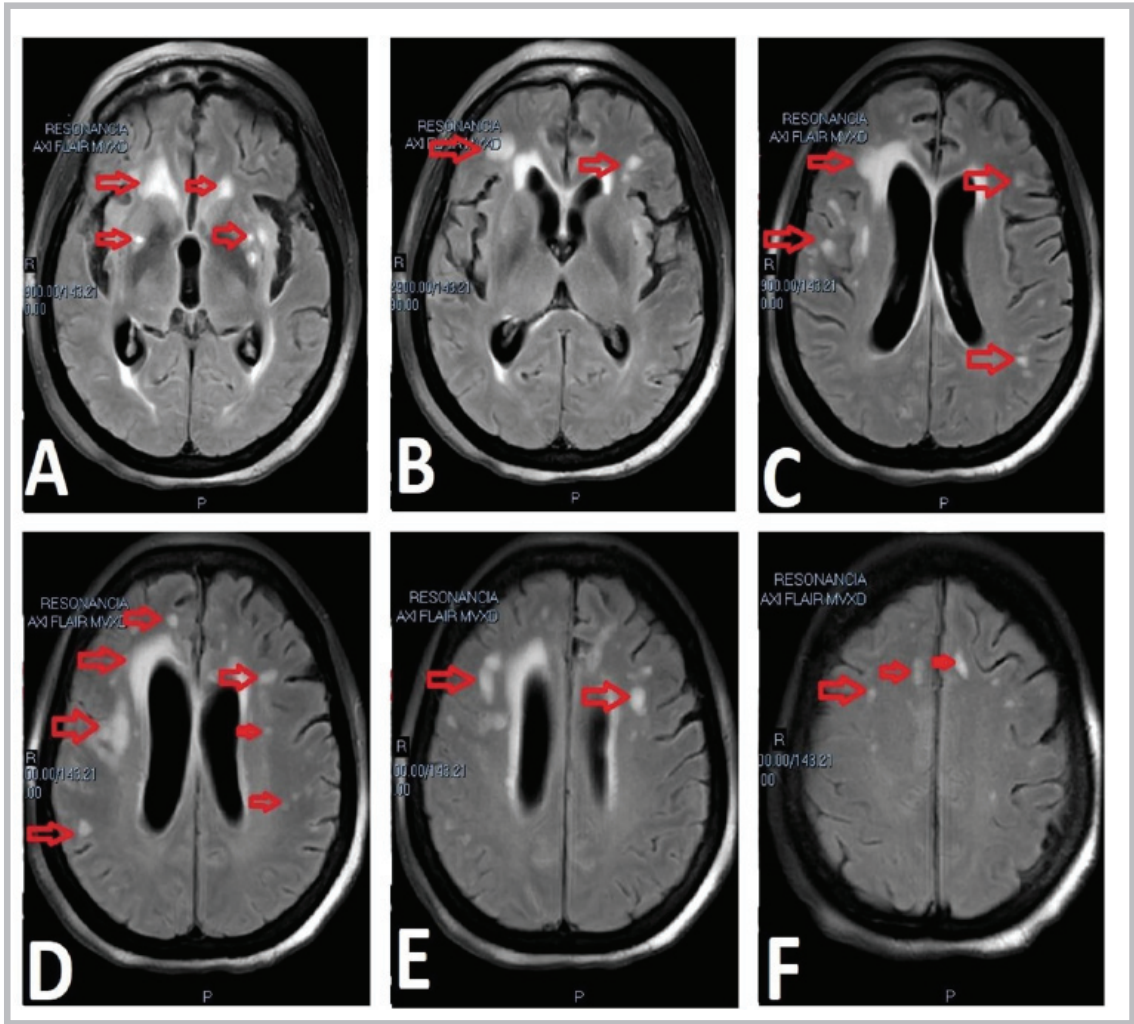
A patient with multiple lesions that are enhanced in the axial section of a FLAIR sequence magnetic resonance; the red arrows identify the lesions. Images A and B show extensive enhancement and involvement of multiple basal ganglia lesions. Figures C, D and E emphasize the subependymal and white matter involvement. Finally, Figure F shows enhanced lesions resembling white matter disease.
